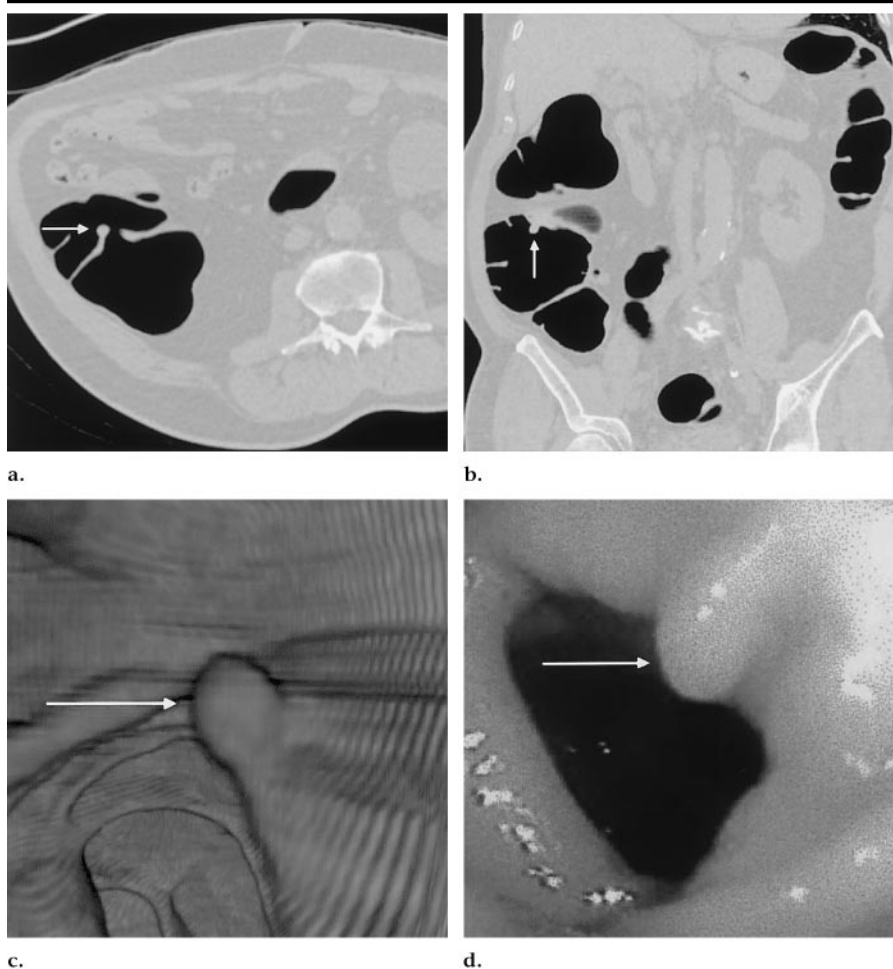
Round polyp (6 mm) in 71-year-old man. (a) Transverse CT colonographic image shows a 6-mm mass (arrow) with smooth round borders on a haustral fold in the ascending colon. (b) Coronal CT colonographic image findings confirm that the mass (arrow) seen in a has a smooth round polypoid morphologic structure. (c) Three-dimensional volume-rendered endoluminal CT image shows the polyp (arrow) to have a round morphologic structure and smooth borders. (d) Corresponding colonoscopic image shows the same round polyp (arrow) with smooth borders.
